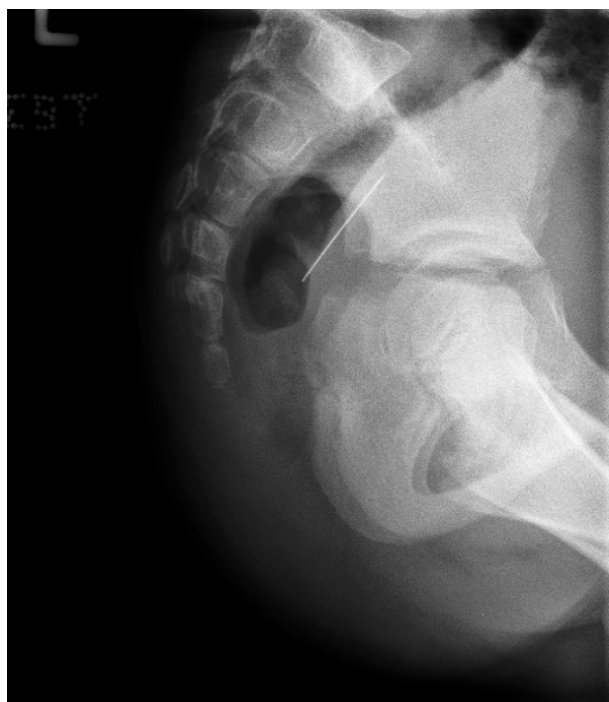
Abdominal x-ray 17 days after ingestion of the pin
